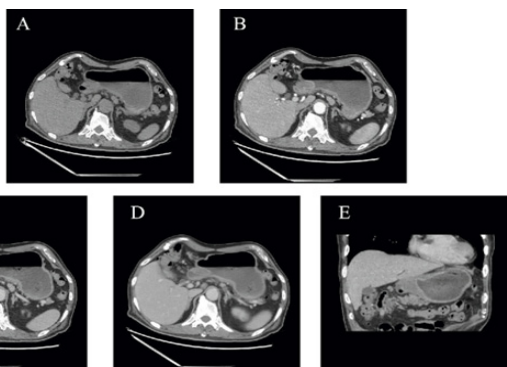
Abdominal plain and contrast-enhanced CT scans. (A) Non-contrast abdominal CT; (B) Arterial phase; (C) Venous phase; (D) Equilibrium phase; (E) Coronal CT view.
